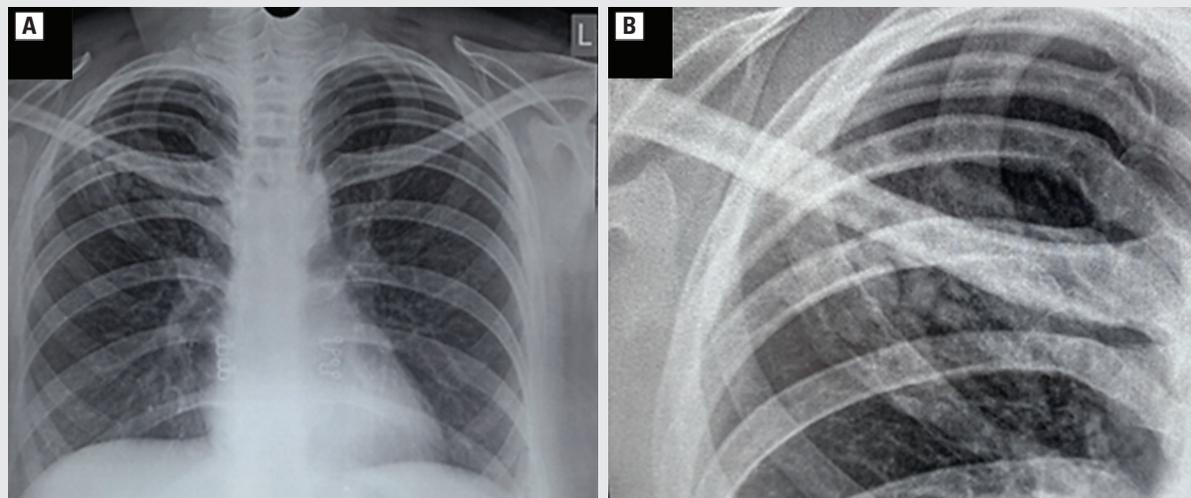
A. Chest X-ray posteroanterior view showing a lobulated opacity in the right upper zone. B. Magnified view showing curvilinear opacities extending from the hilum suggestive of a pulmonary arteriovenous malformations (AVM)
